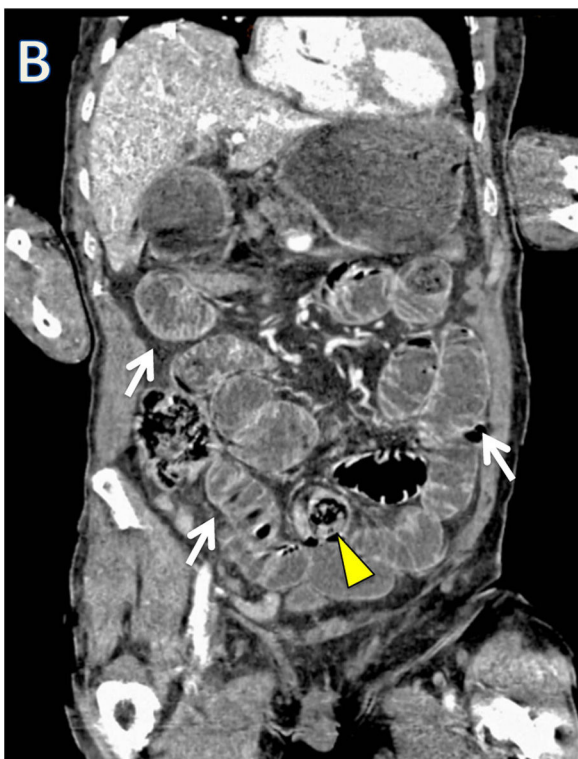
Abdominal CT axial and coronal showing small bowel loops distension (arrows) and an oval formation in a distal jejunal bowel loop.
